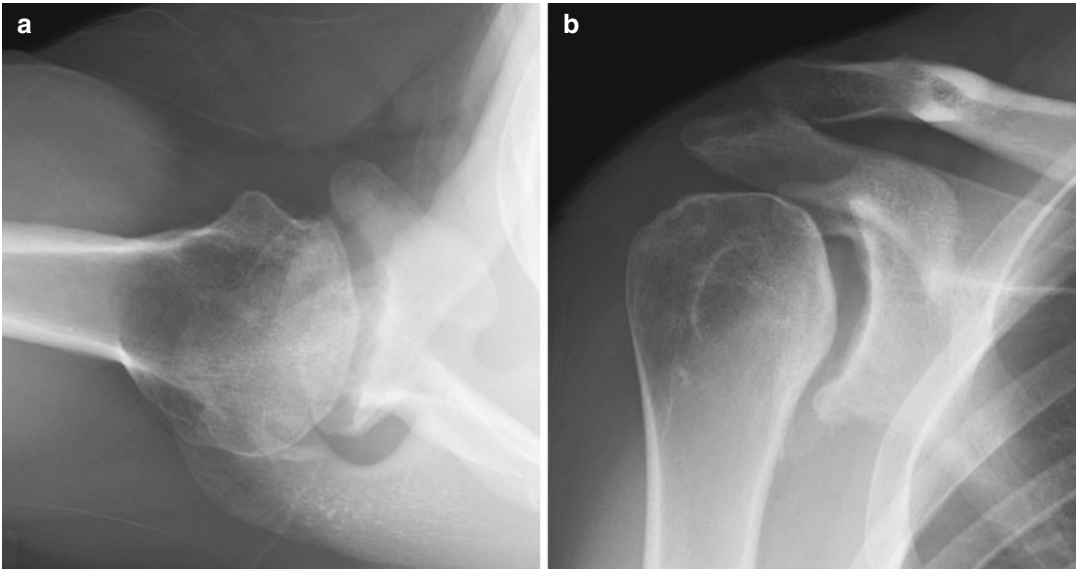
Right shoulder postoperative (a) axillary and (b) Grashey radiographs 2 years after AGR in a 32-year-old man with chondrolysis
